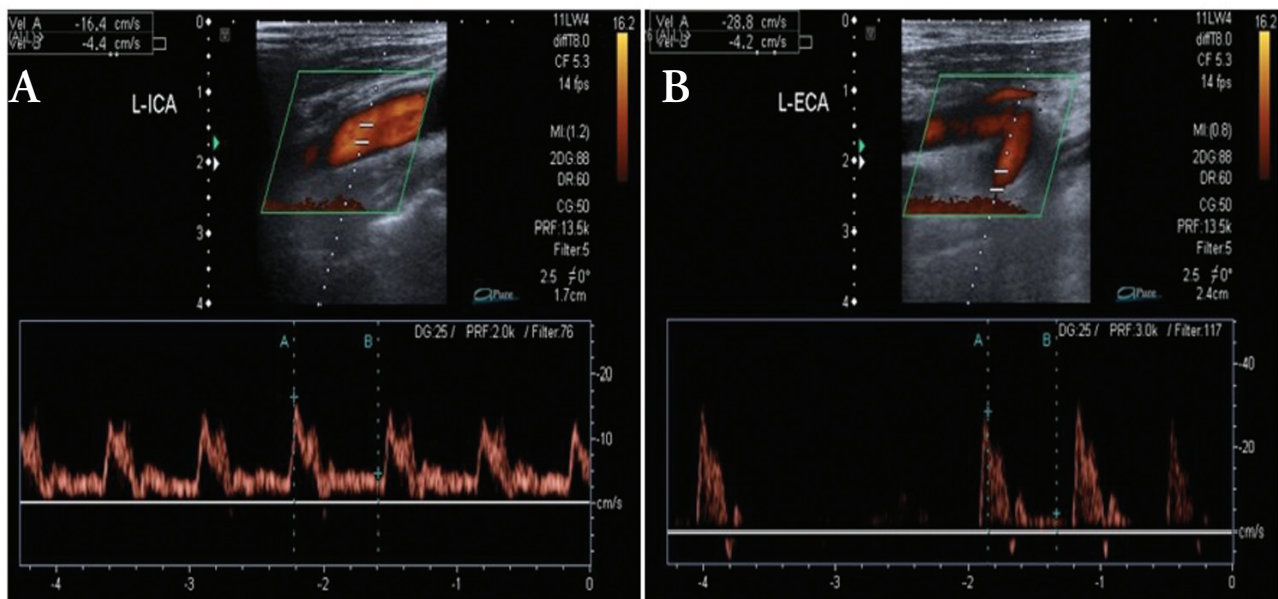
Normal doppler waveforms of A) internal carotid artery (ICA) (left image) and B) External carotid artery (ECA) (right image).
